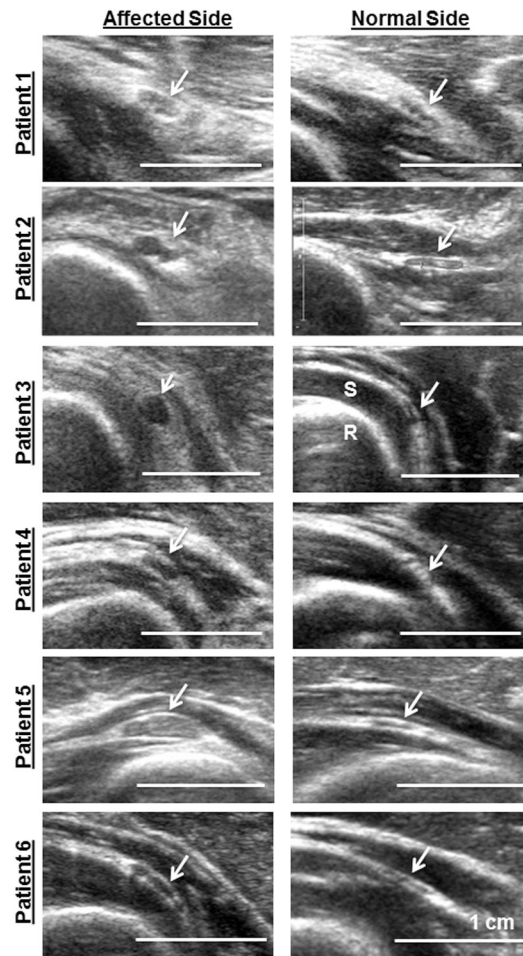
Ultrasound images of the enlarged posterior interosseous nerve (arrows, left panels) compared to the normal, contralateral side (arrows, right panels) in 6 patients with electrodiagnostic evidence of a radial neuropathy. The radius (R) appears as bright and rounded deep to the supinator (S). White bar = 1 cm.
